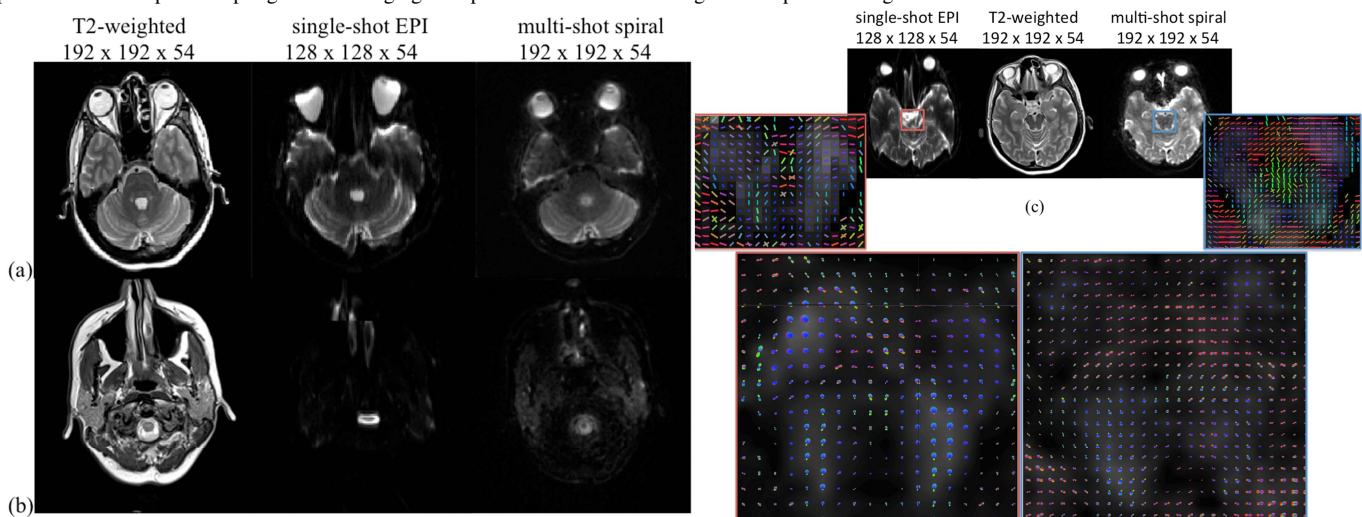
Comparison of multi-shot spiral and single-shot EPI axial diffusion images in brain regions that are affected by susceptibility artifacts. (a) & (b) shows the T2-weighted image, Single-shot EPI and Multi-shot spiral images of the same slices in the cerebellum and cervical spine respectively. The geometric distortions in the single-shot EPI even for moderate resolutions are significant. Multi-shot spiral imaging provides better quality images in these regions. (c) shows an axial slice from the region of the pons and the color coded primary diffusion directions from the boxed region. In the bottom row, the diffusion ODFs from the region are shown for the single-shot EPI and multi-shot spiral. At the higher resolution obtained using the multi-shot spiral imaging, the complex neuronal fiber orientations such as the transverse pontine fibers can be observed in greater detail. This region suffers from significant artifacts using single-shot EPI.
